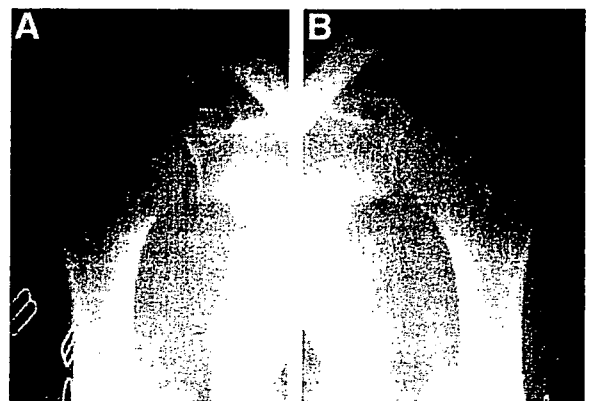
Radiographs of the rheumatoid shoulders of a 52-year-old woman. A, The right shoulder was at glenohumeral joint destruction (GHD) grade 1 and had a mild grade of greater tuberosity destruction (GTD). It showed no pronounced osseous lesion. B, The left shoulder was at GHD grade 2 and a severe grade of GTD. It showed an extensive osseous lesion in the greater tuberosity, but the original articular surface had not yet disappeared. The destruction pattern was uniformly mild/GTD type. The destruction was asymmetrical.
